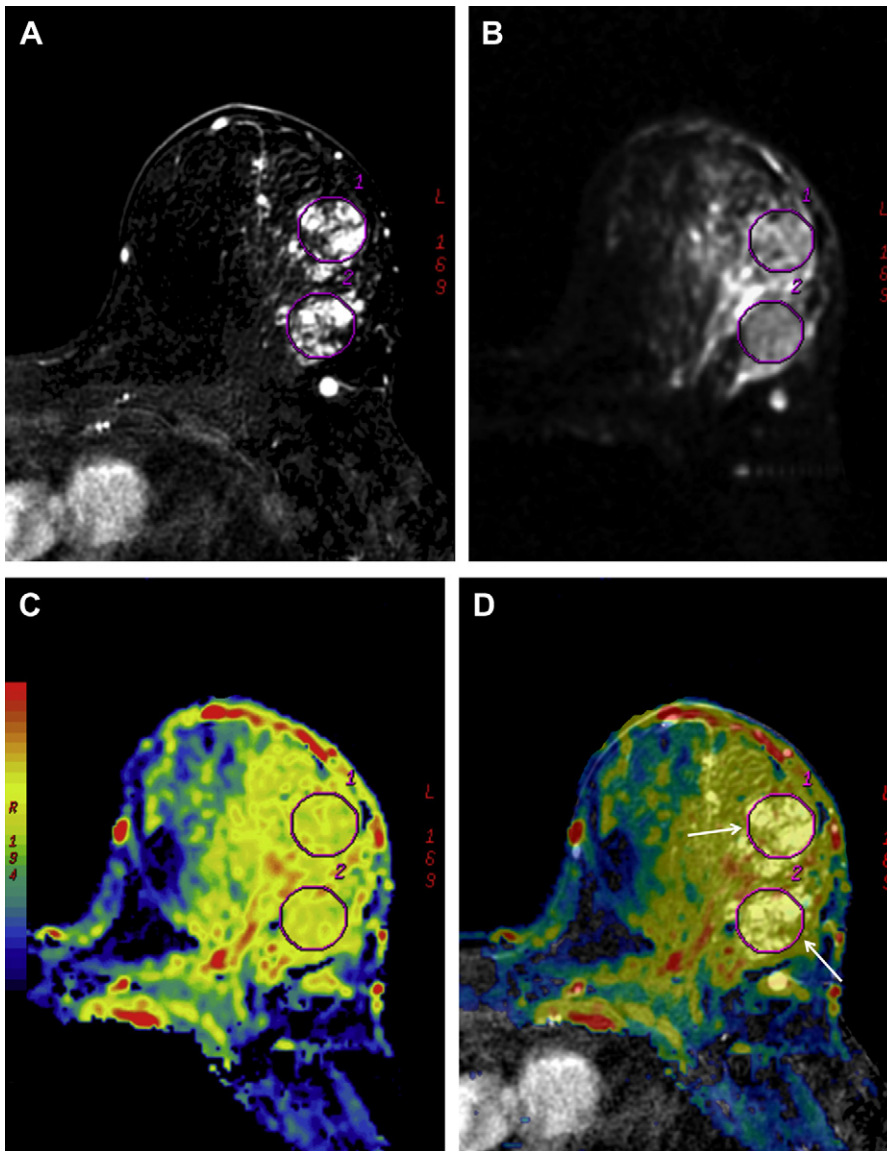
62-year-old woman with nonmasslike enhancement of the left breast. (A) Axial contrast-enhanced T1-weighted three-dimensional spoiled gradient-echo image, first phase, subjected to subtraction technique. (B) Axial diffusion-weighted image. (C) Axial colored ADC map obtained using b-values of 0 and 750 s/mm^2 . (D) Fusion axial contrast-enhanced T1-weighted subjected to subtraction technique and axial colored ADC map reveal a nonmasslike enhancement lesion classified as highly suspicious by conventional MR imaging. Because nonmasslike enhancement lesions form large but noncompact lesions, a lesser restriction of the diffusion processes may occur, evident as yellow, and not blue, on the ADC colored map. Note that even using the subtracted image as reference to the ROI placement, there are still no enhancing areas, which may not represent tumor inside the ROIs (*white arrows*).
